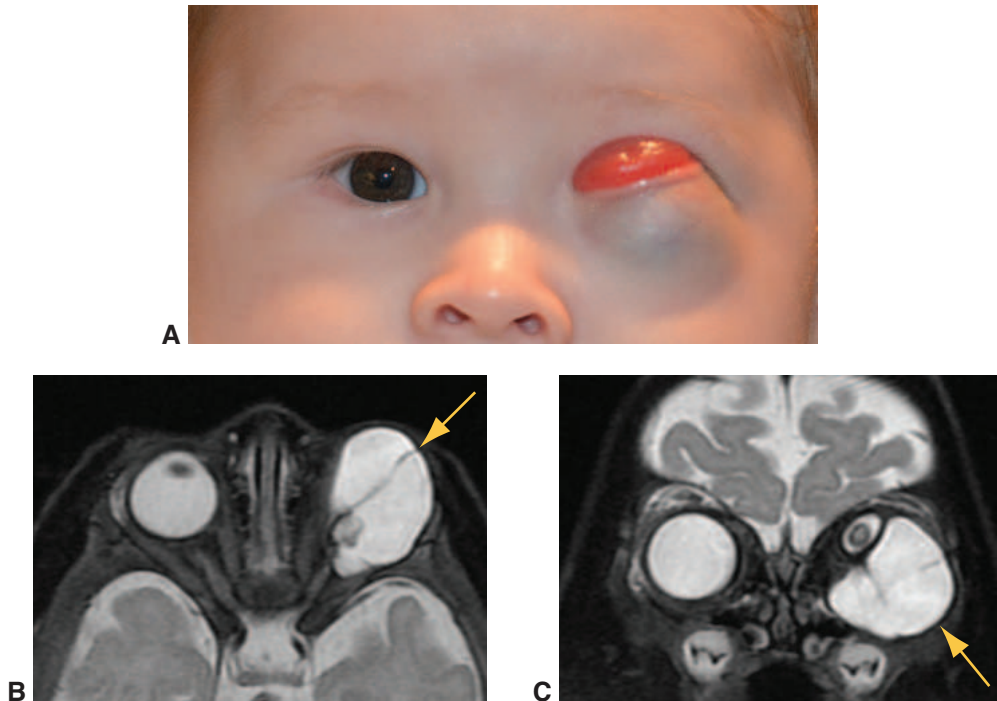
Microphthalmia with orbital cyst. A, Infant exhibiting left microphthalmia with orbital cyst. B, Axial T2-weighted magnetic resonance (MR) image and C, coronal T2-weighted MR image, demonstrate presence of a vestigial eye and a large orbital cyst on the left side (arrows). (Courtesy of Don O. Kikkawa, MD.)
